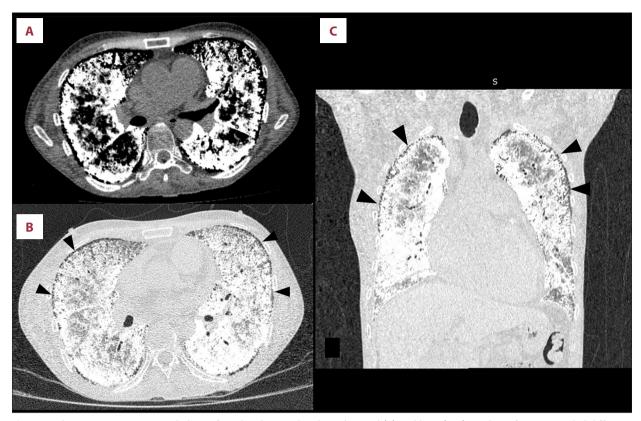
Chest HRCT. Reconstructed plane of axial and coronal with mediastinal (A) and lung (B, C) window of HRCT revealed diffuse micronodular calcification along the interlobar septa and subpleural regions in the lower pulmonary regions, with ground-glass attenuation and septal thickening in between. Multiple cysts were also noticed along the subpleural line (arrow head).
